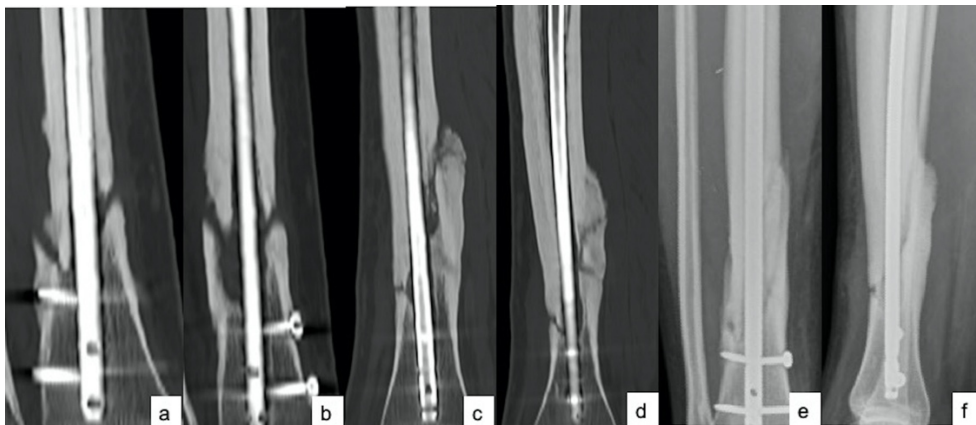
Paramedian (#4 and #6) coronal (a,b), sagittal (c,d) CT reformats and AP and lateral radiographs (e,f) of a nailed tibial non-union with high RUS. The score-ratio between the sum of the cortical scores and the maximum score obtained on the CT reformats (11/36) is lower than that obtained on the x-rays (10/16).
